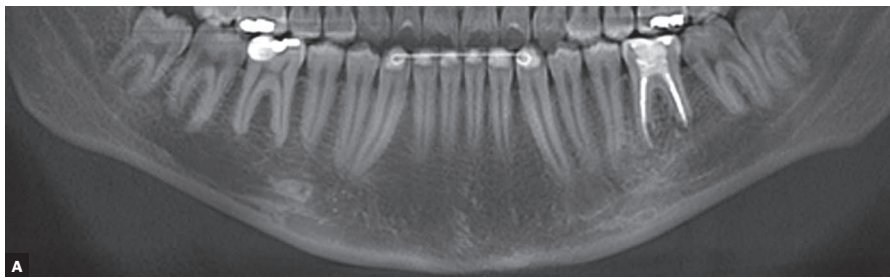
CBCT (June/2017). (A) coronal-panoramic image. (B) sagittal image. (C) axial image.
